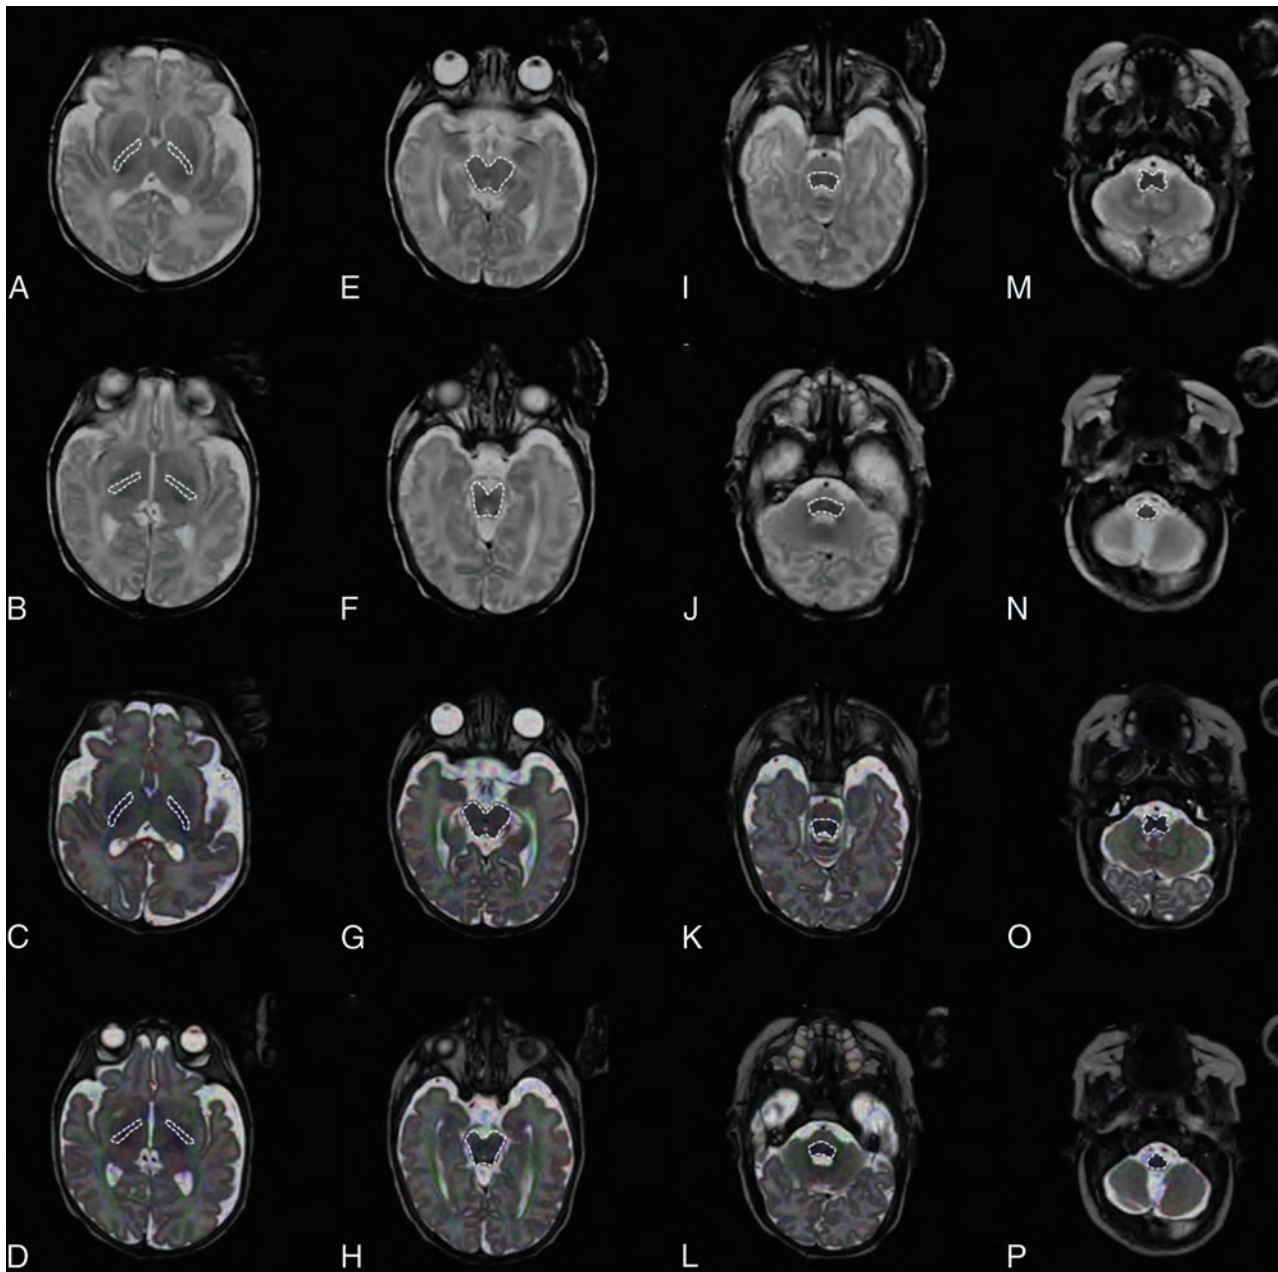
ROI placement is demonstrated on an SyMRI-generated T2-weighted MR imaging contrast (A, B, E, F, I, J, M, N) (TR = 4500 ms; TE = 100 ms; axial plane) and a diffusion tensor map superimposed on a T2-weighted turbo spin-echo sequence-based image (C, D, G, H, K, L, O, P) (TR = 3000 ms; TE = 140 ms; axial plane) of a female infant (GA at birth: 24 + 4 weeks + days; PMA at MR imaging: 39 + 2 weeks + days). For each investigated brain region, 2 separate ROIs were defined at different levels: right/left PLIC (ROI 1: level of the foramen of Monro [A and C]; ROI 2: level of the third ventricle [B and D]); midbrain (ROI 1: level of the superior colliculus/intercollicular area [E and G]; ROI 2: level of the inferior colliculus [F and H]); pontine tegmentum (ROI 1: level of the locus coeruleus [I and K]; ROI 2: level of the superior olive [J and L]); and medulla oblongata (ROI 1: level of the inferior olive [M and O]; ROI 2: level of the dorsal column nuclei [N and P]).
